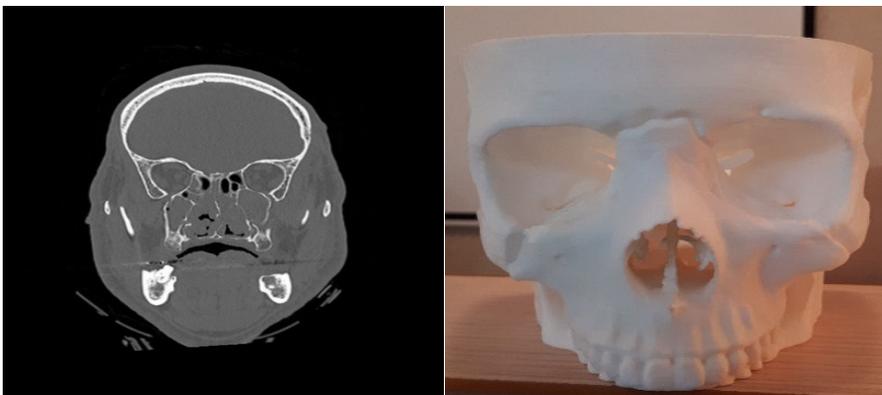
CT scan and 3D model of Le Fort II fracture
